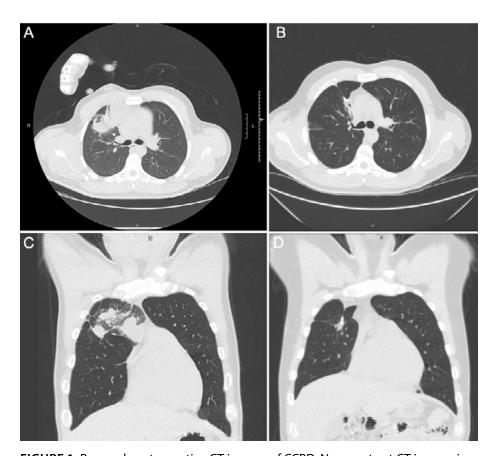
Pre- and postoperative CT images of CCPD. Non-contrast CT images in coronal and sagittal planes viewed through lung window. Postoperative images completed 4 months post wedge resection. A: CT guided biopsy of cystic right anterior lobe mass completed May 2020. B: Postoperative view of upper lobe reveals no evidence of mass or cystic components. C: Sagittal view of right anterior upper lobe reveals multiple cystic-appearing components with the largest seen against the mediastinum. Completed December 2019. D: Postoperative sagittal view reveals no evidence of lung mass.
